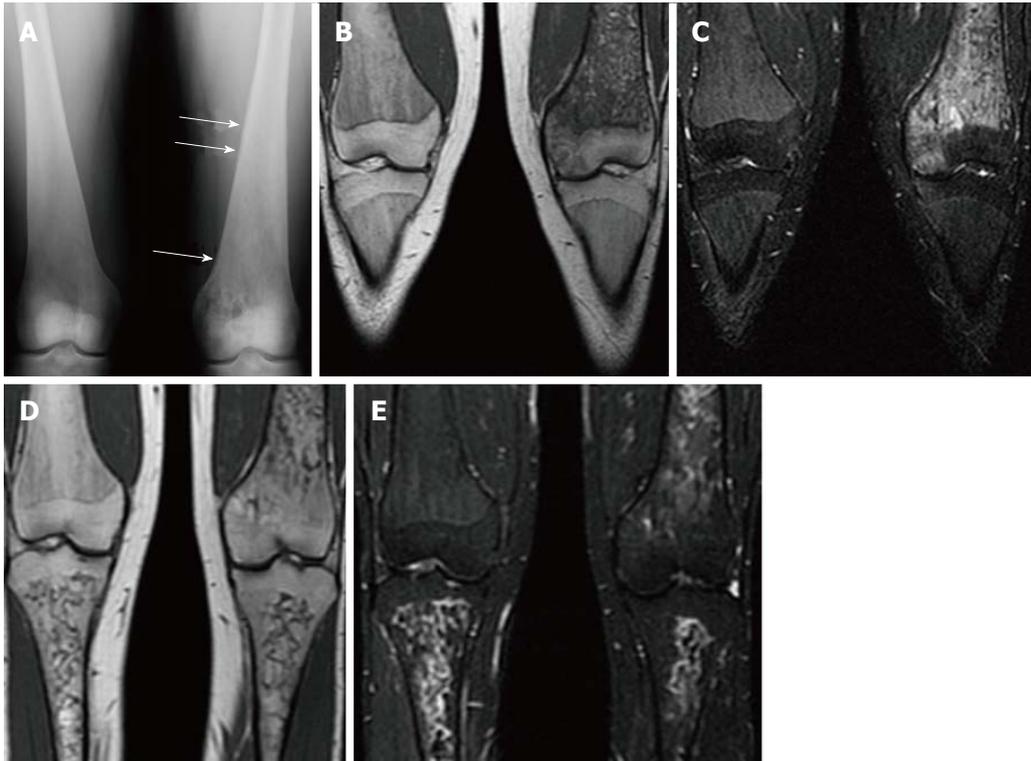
Pseudo-osteomyelitis. Frontal radiograph of both distal femurs in 2009 (A) demonstrates an irregular area of patchy lucency in the medial condyle of the left femur. There is periosteal reaction in this area as well as more superiorly (arrows). Coronal T1 WI (B) image at the same time in 2009 demonstrate low SI in the medial condyle of the femur extending into the medial epiphysis. There is high SI in these areas on coronal STIR (C) image which extends into the adjacent soft tissues where the periosteal reaction is seen on the radiograph. There is no joint effusion. The patient presented with left knee pain and the imaging was suspicious for osteomyelitis involving the medial distal femur. However, the patient has no fever and cultures were negative. Coronal T1 WI (D) of the same area in 2011 shows resolution of the low SI in the medial condyle and epiphysis. The corresponding high SI on the STIR image (E) has resolved as well.
